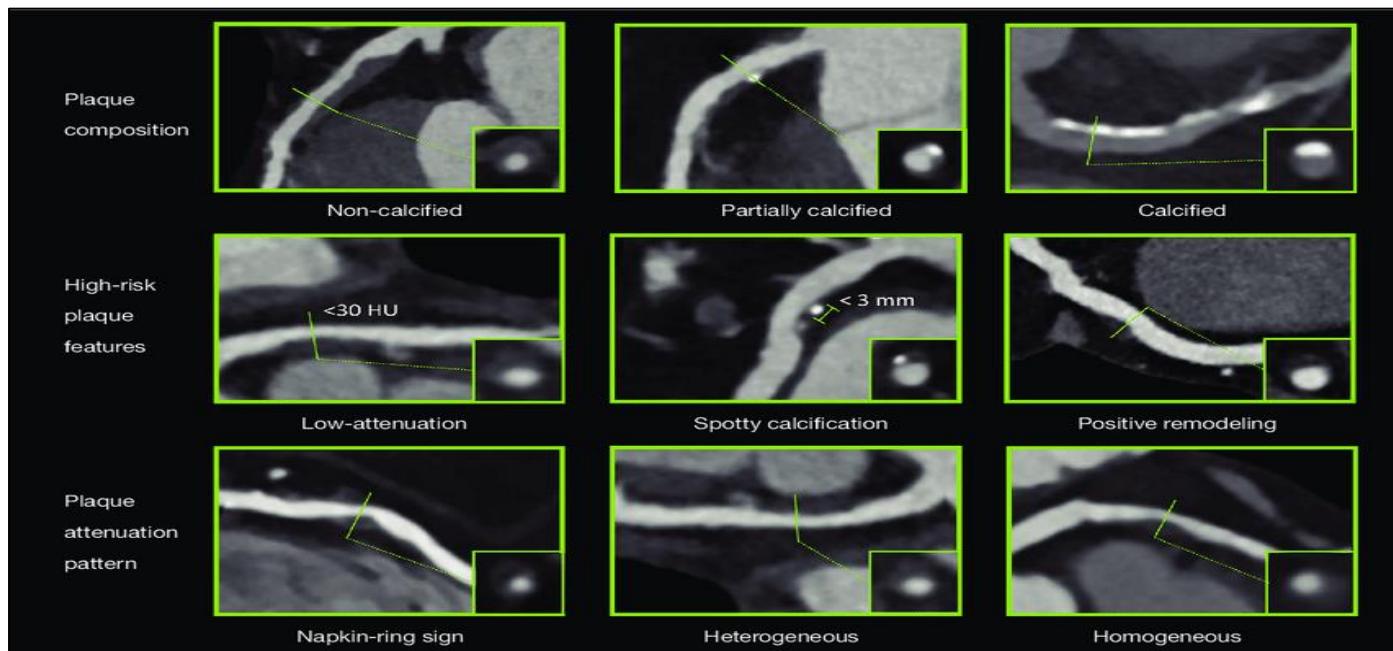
Representative Images of Plaque Characteristics (Non-Calcified, Mixed, Calcified) with Colour Overlays from CT
